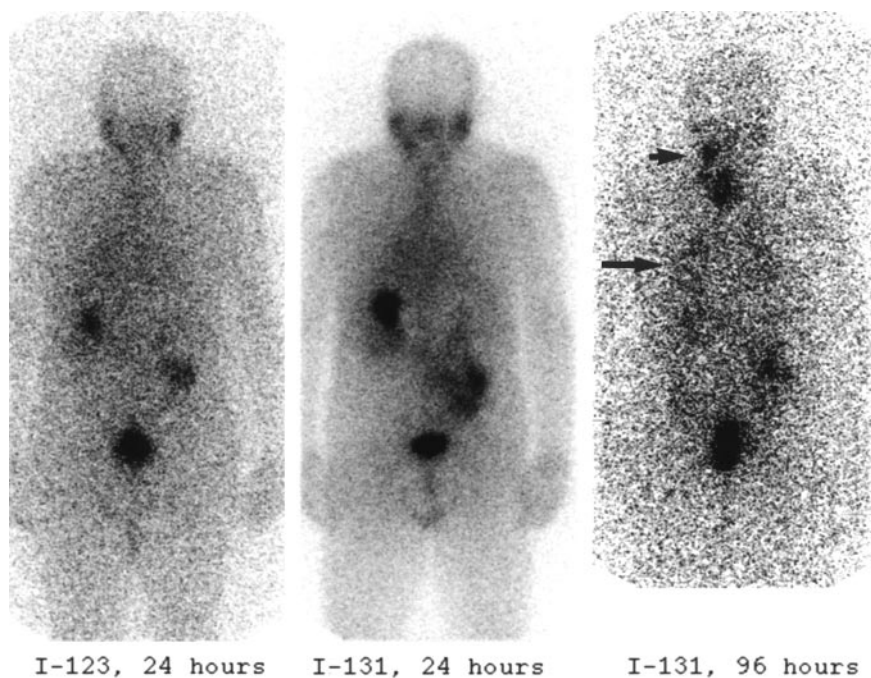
An 81-y-old man with papillary thyroid cancer presented with radiographic evidence of pulmonary metastases. Posterior whole-body images at 24 h with ^{123}I (left) and ^{131}I (middle) are unremarkable (thyroid bed uptake was noted with both tracers on anterior images, not shown). Stomach and bowel activities are noted in abdomen. Posterior ^{131}I image at 96 h (right) shows uptake in pulmonary and left cervical metastases (arrows).
